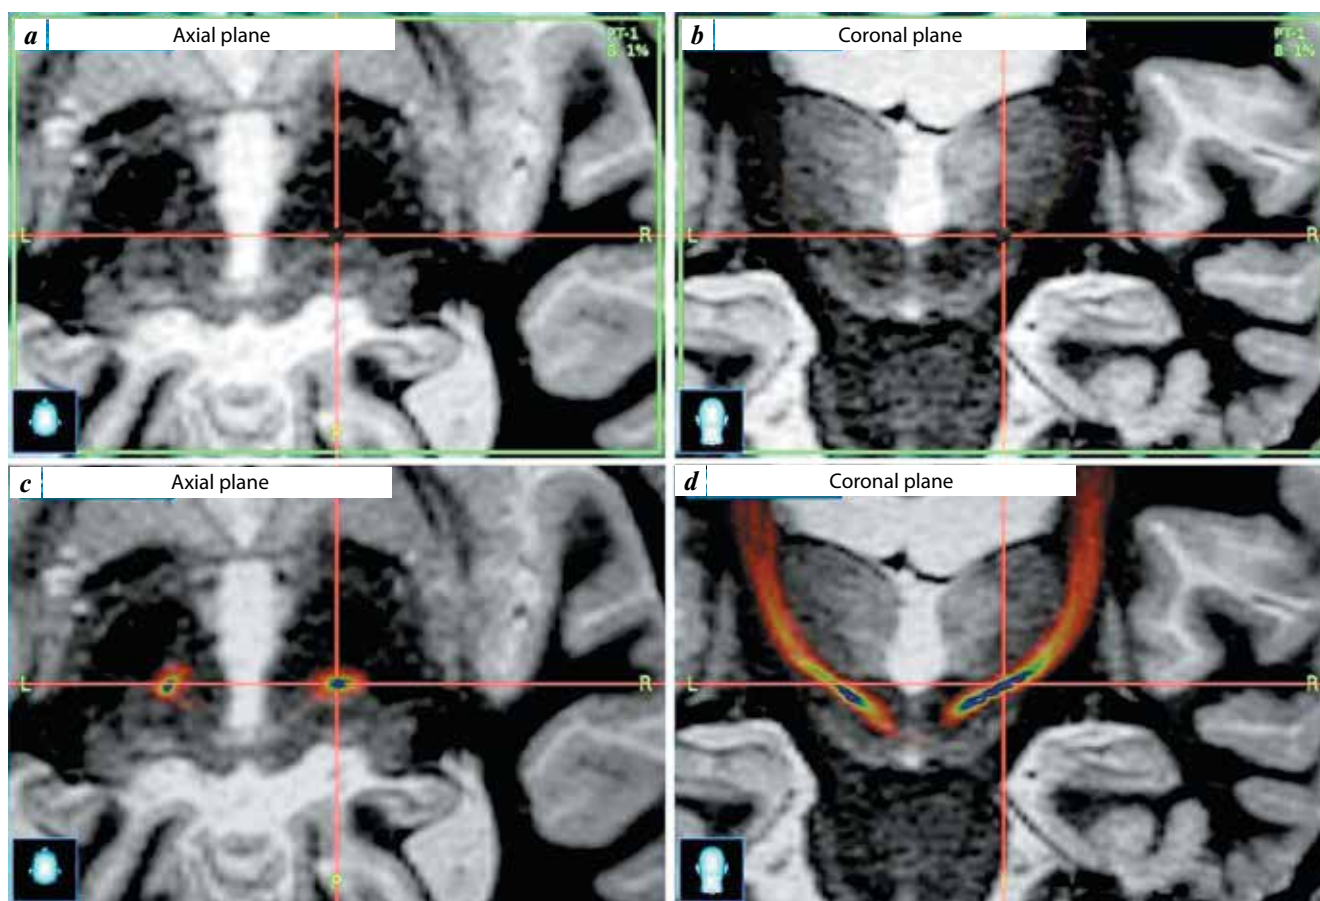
Magnetic resonance imaging (MRI) of the brain in FGATIR mode, the window of the Cranial Medtronic StealthStation S7 program: structural MRI (a, b) and the superimposition of dentato-rubro-thalamic tract (DRT) MRI tractography on structural MRI (c, d); MRI reconstruction in the axial plane (a, c) and in the coronal (b, d). The hypointensive zone laterally to the upper parts of the red nucleus corresponds to the passage of the DRT. The crosshair corresponds to the center of the hypointensive zone
